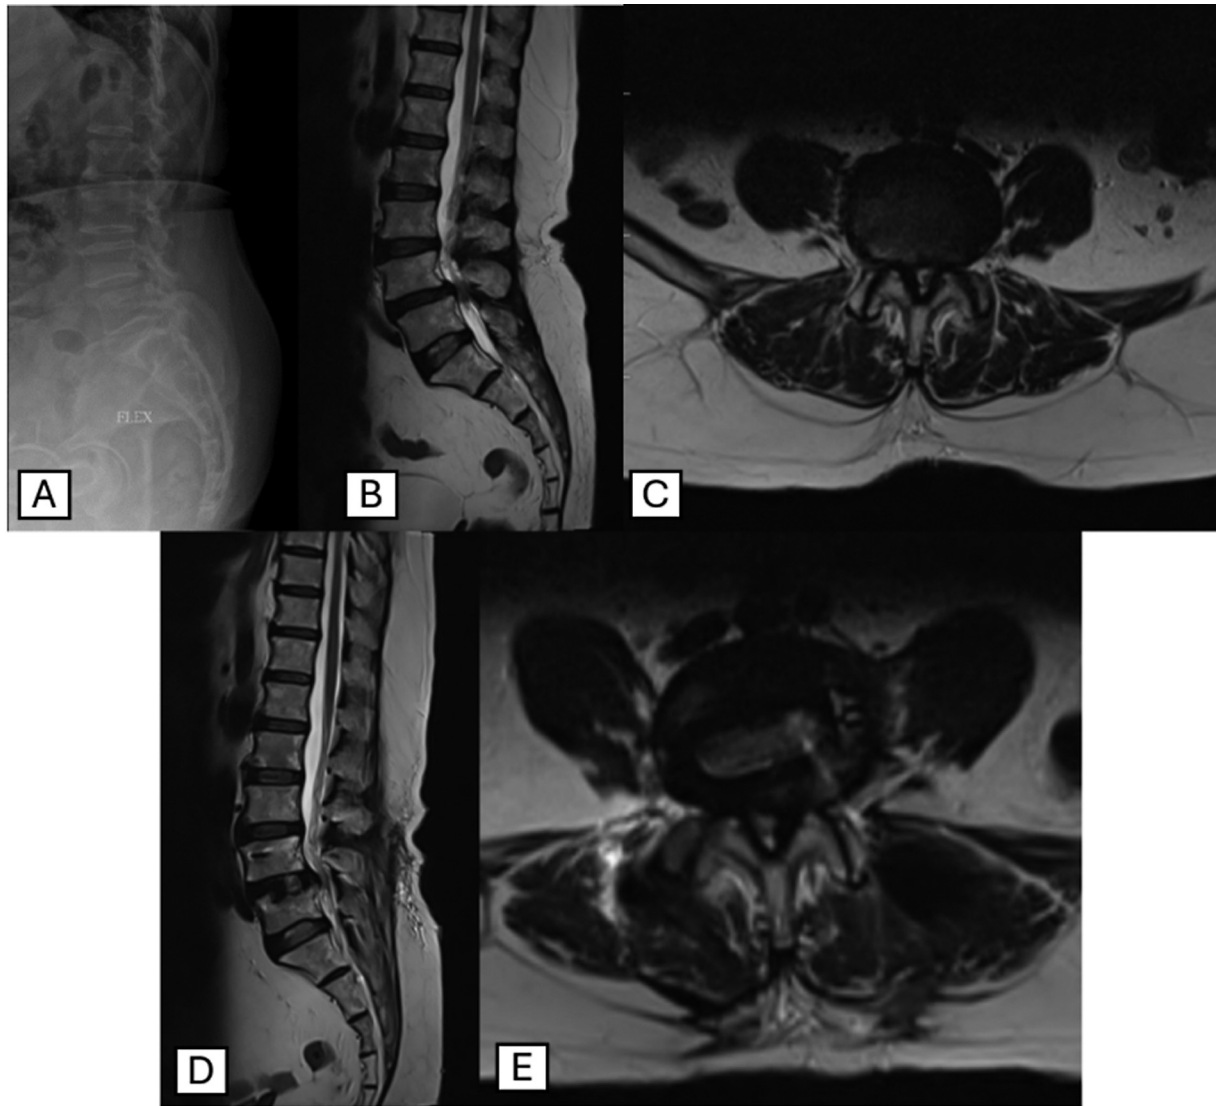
Preoperative lateral X-ray (A) and T2-weighted (T2W) magnetic resonance imaging (MRI)—midsagittal section (B) and axial section at L4–5 level (C) who underwent L4–5 transforaminal lumbar interbody fusion (TLIF), showing grade 1 degenerative spondylolisthesis with severe lumbar canal stenosis (LCS). Patient developed recurrence of claudication symptoms after 1 year of surgery. T2-weighted midsagittal (D) and axial MRI images at L4–5 level (E) done at 1-year follow-up showing recurrence of stenosis. Revision posterior decompression was done after 1 year of initial surgery.
